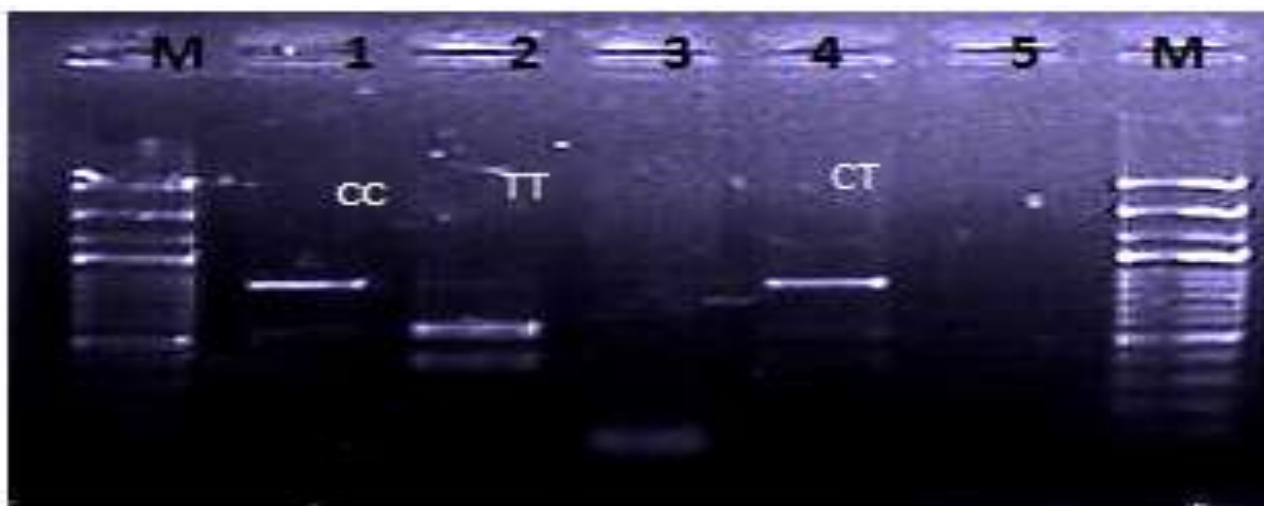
The electrophoresis pattern of RFLP-PCR for PCR product (881 bp) with restriction enzyme *NCOI*, 3% agarose, 75 V, 20 Am for 120 min. (10 μ l in each well). Lane M: DNA ladder 100 bp Lane 1, showing wild homozygote (CC 881bp) genotype. Lane 2, showing mutant homozygote (TT530, 351bp) genotype. Lane 4, showing mutant heterozygote (CT 881,530,351) genotype
